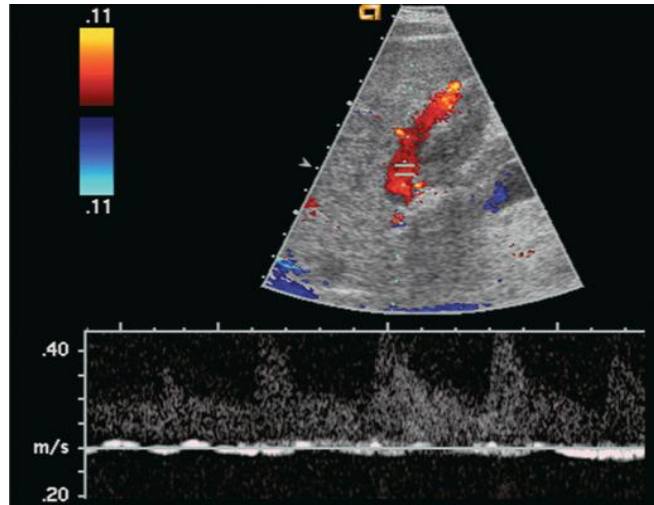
(A): Spectral Doppler tracing of a patient with end-stage liver disease being considered for liver transplantation. With neutral breath hold, flow in this portal vein is barely perceptible. It oscillates between hepatofugal during arterial systole and hepatopetal during arterial diastole.
